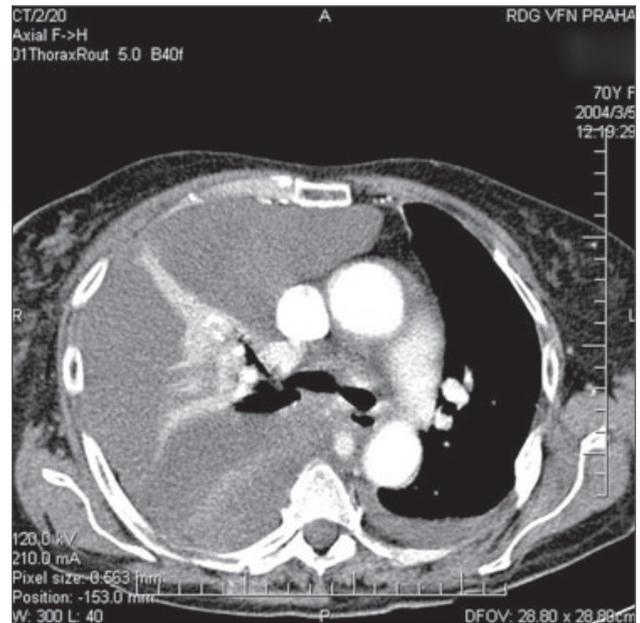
CT examination again excluded an aortal lesion.
